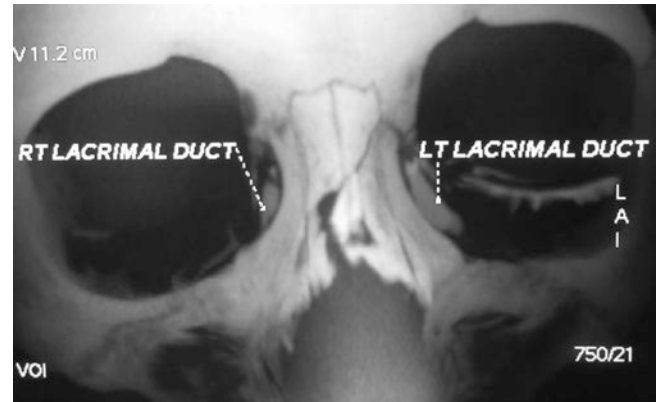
CT-DCG in a trauma setting showing accumulation of the dye in the left lacrimal sac indicating an obstruction below in a case of naso-orbito-ethmoid fractures
